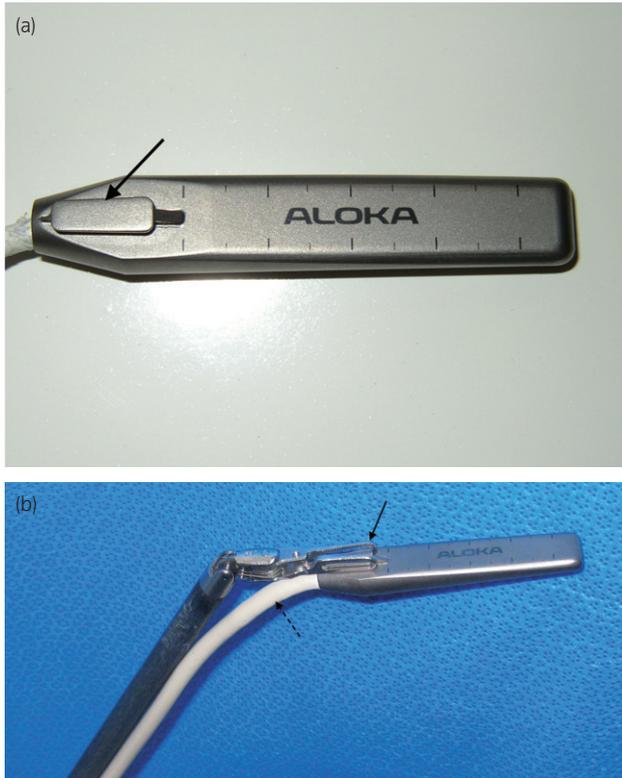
(a) Robotic ultrasound probe used for tumor identification during RPN. The robotic ultrasound probe has a grooved ridge on its ventral aspect (solid black arrow) that fits the robotic grasping instrument. (b) Robotic ultrasound probe with notch attached to robotic instrument (solid black arrow). The probe has a flexible cable (dashed black arrow) that allows passage through the assistant port and allows for full articulation of the robotic instrument.
